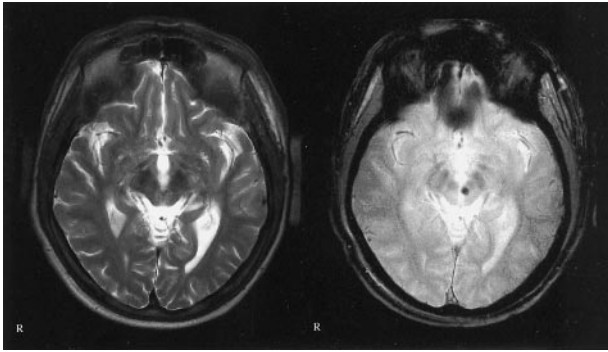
Images of a 37-year-old man who was a pedestrian in a traffic accident in January 1992; he was hit by an automobile while under the influence of alcohol. Traumatic microbleed is shown in the left midbrain, adjacent to the red nucleus, 99 months after traumatic brain injury. *Left*, T2-weighted image; *right*, T2*-weighted image. GCS score, 4; GOS score, 4.
